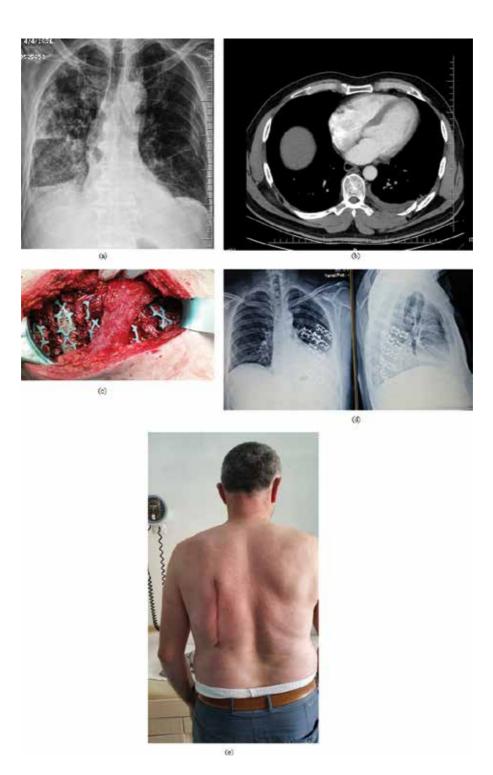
PA radiography, thorax CT and surgical fixation of the ribs of a patient with left multiple rib fractures developed following blunt thoracic trauma, and the post-operative appearance of the patient's skin incision scar.
